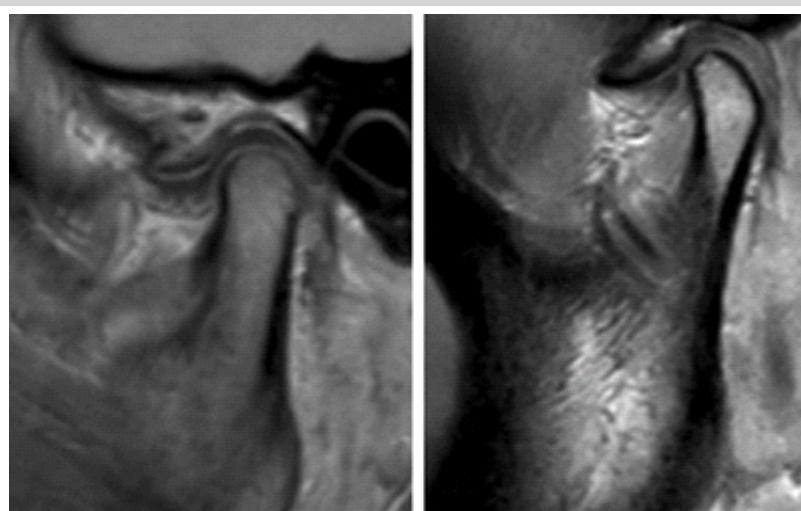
Temporomandibular joint magnetic resonance imaging evaluation with arthritis seen in the joint space.
